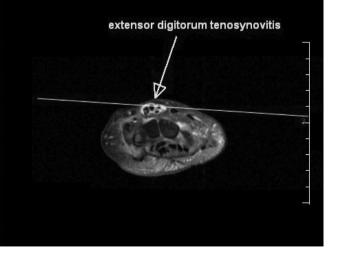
Coronal and axial magnetic resonance image with contrast administration detects tenosynovitis at the wrist joint
